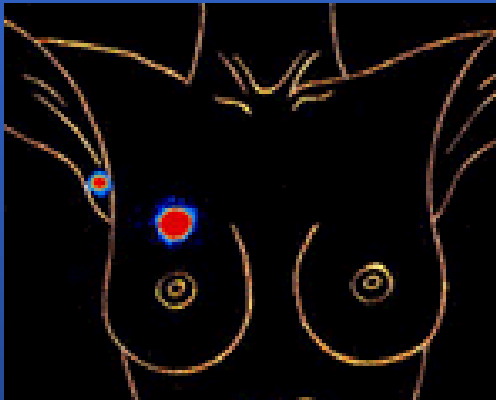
Lymphoscintigram, demonstrating two axillary lymphatic nodes with the largest one located in the left axilla.
